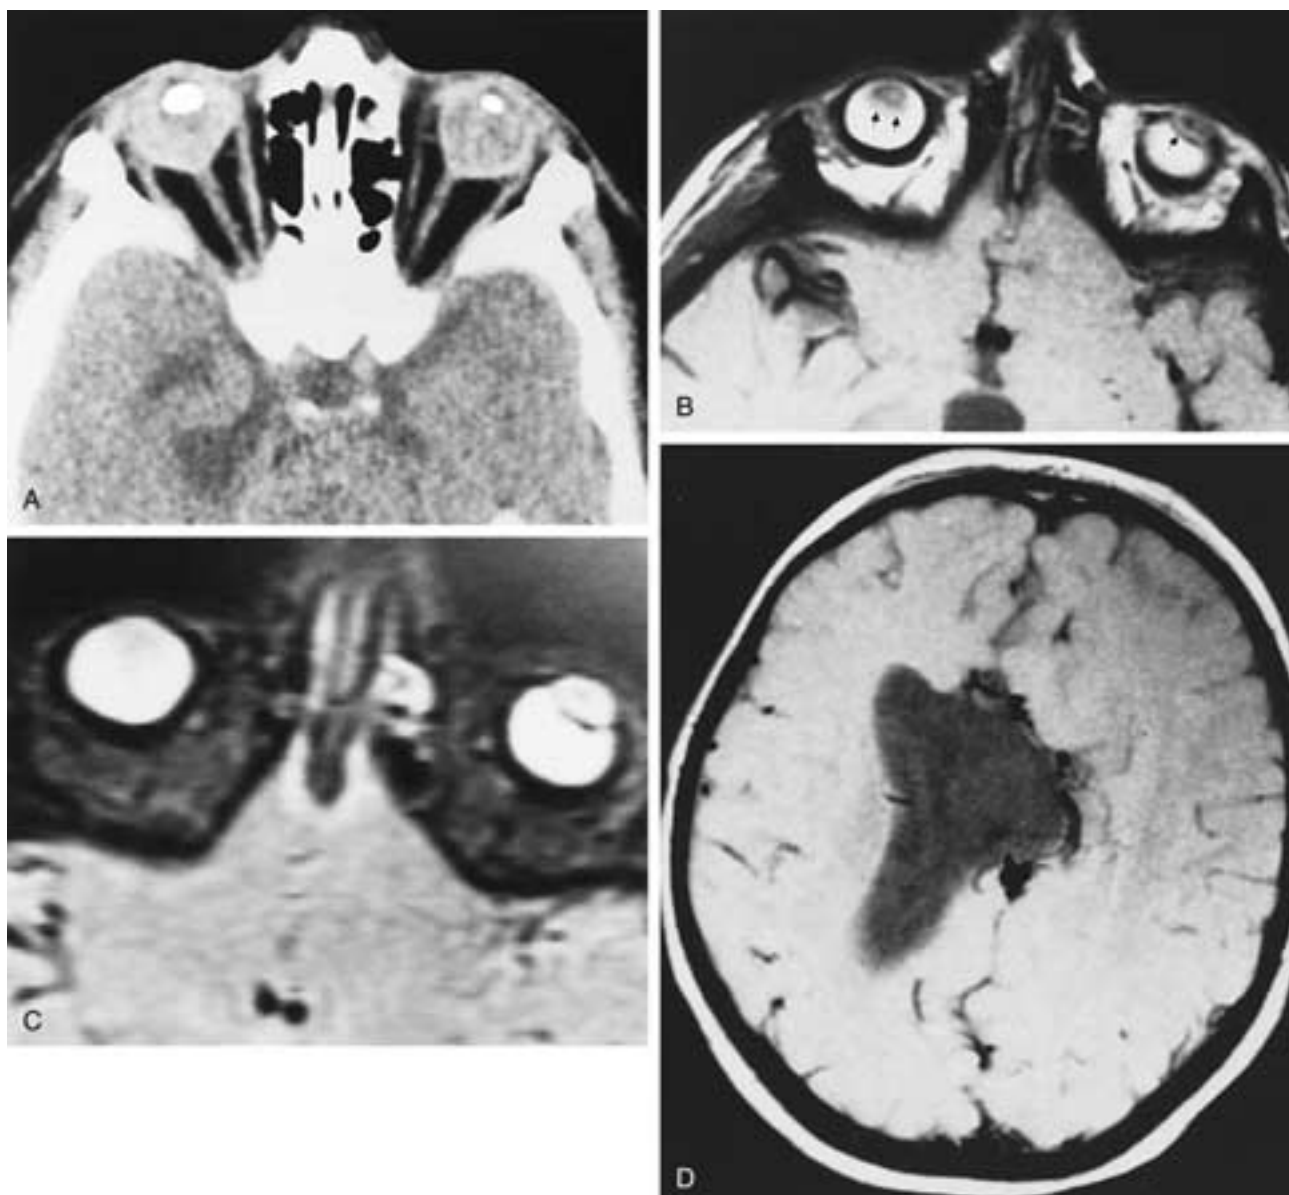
Norrie's disease with bilateral PHPV. A, Axial CT scan shows bilateral dense vitreous chambers and small eyes. The left lens is smaller than the right lens, and both are rather peculiar in shape. B, Axial PW MR image shows marked hyperintensity of both globes. C, Axial T2-weighted MR image shows hyperintensity of both globes. These changes are caused by proteinaceous fluid or chronic hemorrhage in the subhyaloid or subretinal space or within the vitreous chamber. Note the abnormal tissue in the retrolental regions (*arrows*), better seen in B than in C. These changes may be difficult to differentiate from ROP. D, Axial PW MR image shows a developmental anomaly of the lateral ventricles, a cavum septum pellucidum, and flattening of some of the cortical gyri (lissencephaly). (A to C from Mafee MF et al. Persistent hyperplastic primary vitreous (PHPV): role of CT and MRI. *Radiol Clin North Am* 1987;25:683–692.)
